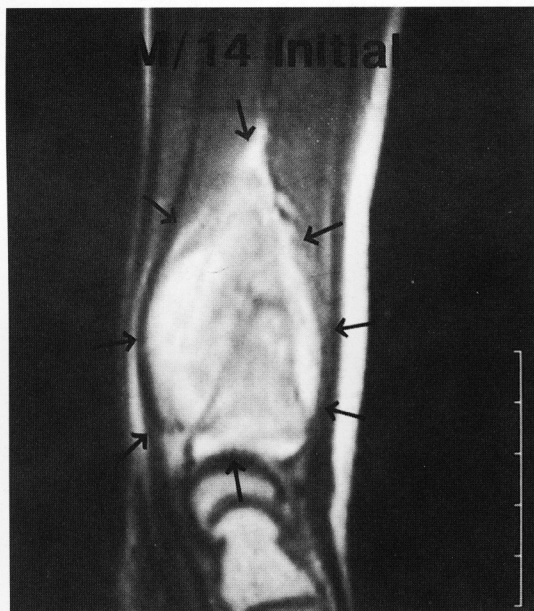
MRI shows high signal intensity on T2 image and peritumoral edema.
